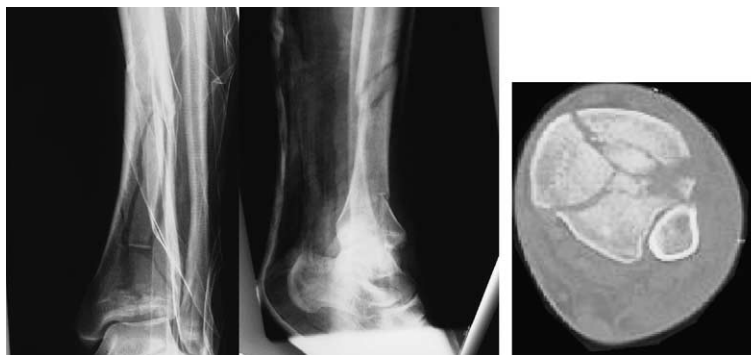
Admission radiographs of tibial plafond fracture sustain in a fall from a height. Compartment syndrome was present, hence a simple quadrilateral frame was applied and fasciotomies performed. CT scanning was then performed with the frame in place.
